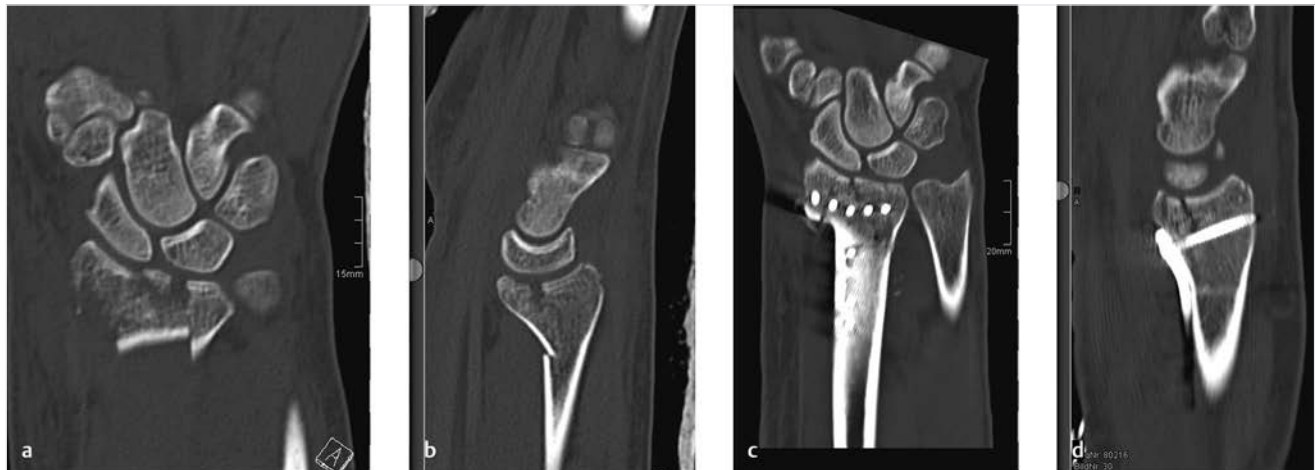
Preoperative CT scans show (a, b) involvement and dislocation of the lunate facet and (c, d) anatomical restoration by a conventional fixed-angle T-plate.
